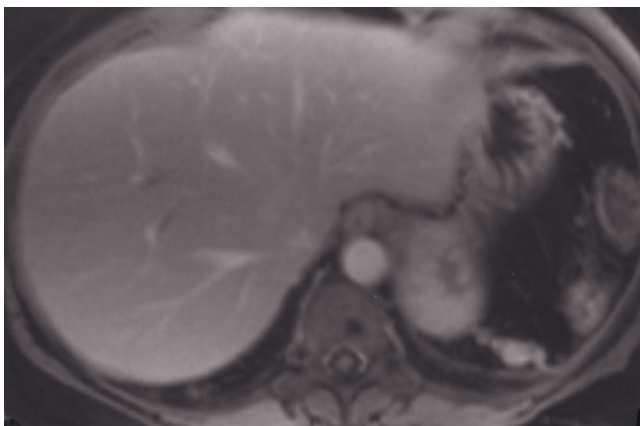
Subcapsular fluid collection secondary to pancreatitis. T1-weighted SGE (a) and 90-s postgadolinium SGE (b) images. A subcapsular fluid collection is present that is slightly high in signal intensity on the T1-weighted image, a finding consistent with the presence of blood or protein (arrows, a). Enhancement of the capsule and surface of the spleen on the postgadolinium image (arrows, b) confirms the subcapsular location of the fluid collection.
